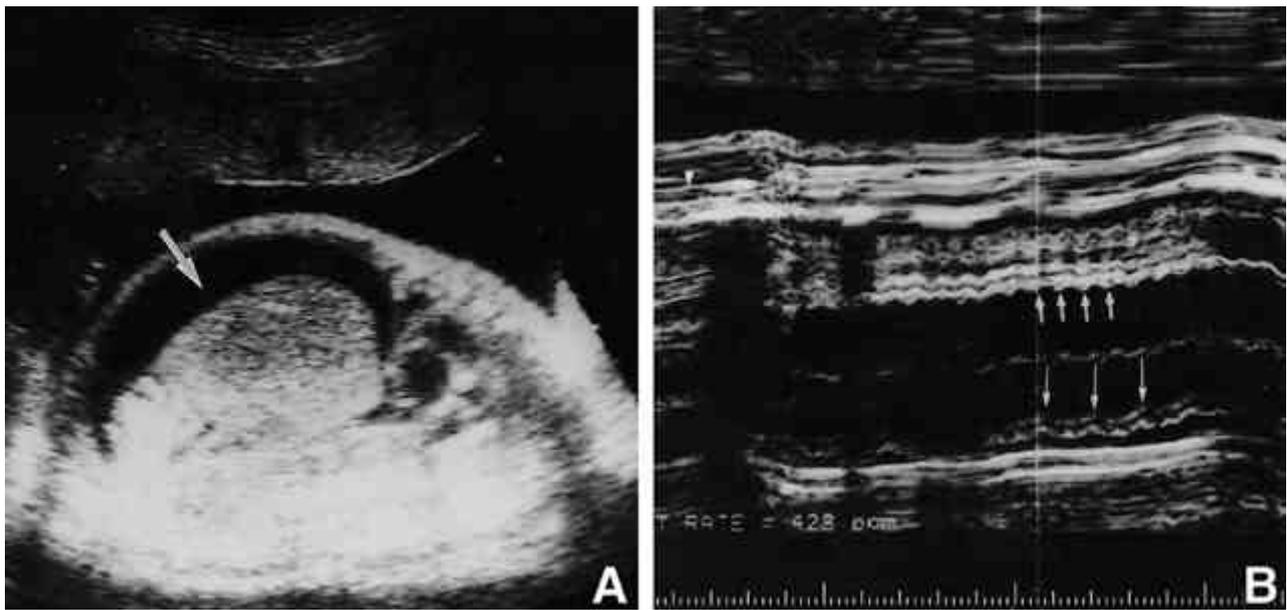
Case 1. A: Initial ultrasonography shows fetal hydrops and polyhydramnios (arrow: ascites). B: Fetal cardiac M-mode shows atrial flutter recorded atrial rate of 400-440 bpm with a 2:1 atrioventricular relation (short arrow: atrial beat, long arrow: ventricular beat).
